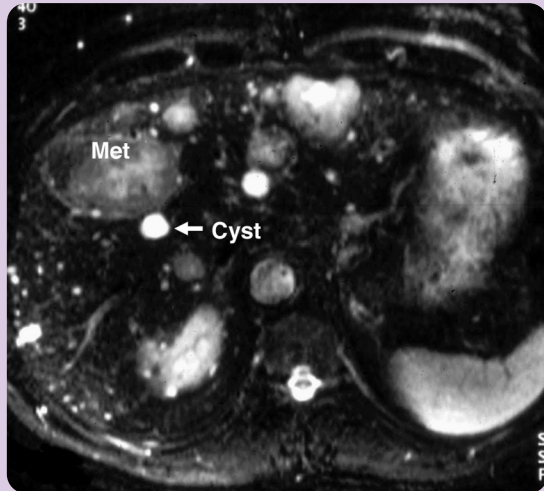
Differentiating cysts from solid masses. A properly selected TE helps differentiate cystic from solid masses, as depicted on this T2-weighted liver MR in a patient with both benign liver cysts and solid liver metastases. Most liver protocols use a TE of approximately 100 msec for this purpose.
